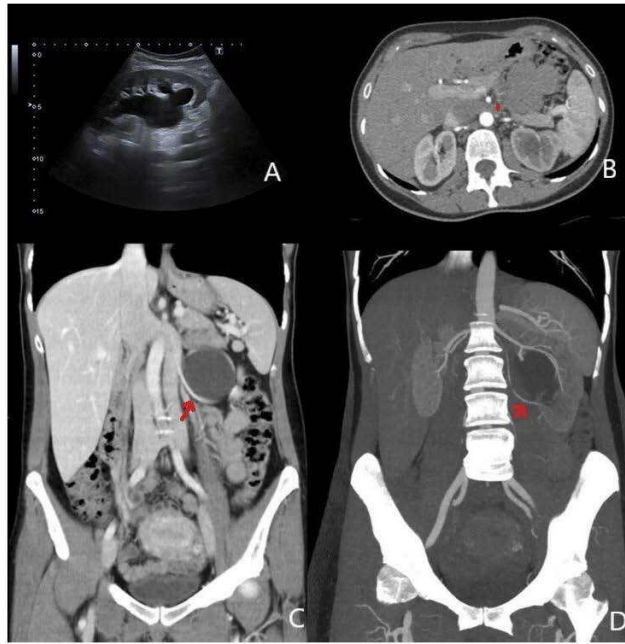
(A).Abdominal ultrasound is requested showing hydronephrosis grade III. (B)Axial contrast CT shows the output of an accessory branch anterior to the renal artery (arrow head). (C) Coronal contrast CT and (D) MIP reconstruction show an accessory artery that stenoses the ureteropelvic junction and produces hydronephrosis (red arrows)
